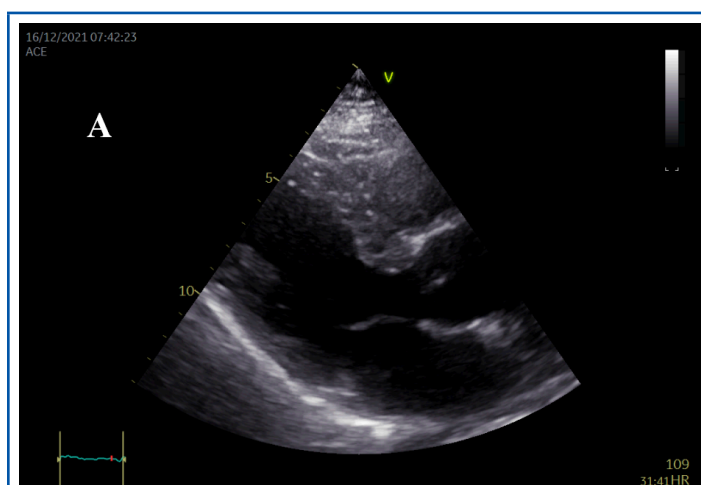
Postoperative 2D-transthoracic echocardiography. Parasternal long axis view confirms the absence of the previously described mass, with normal function of the aortic valve.
